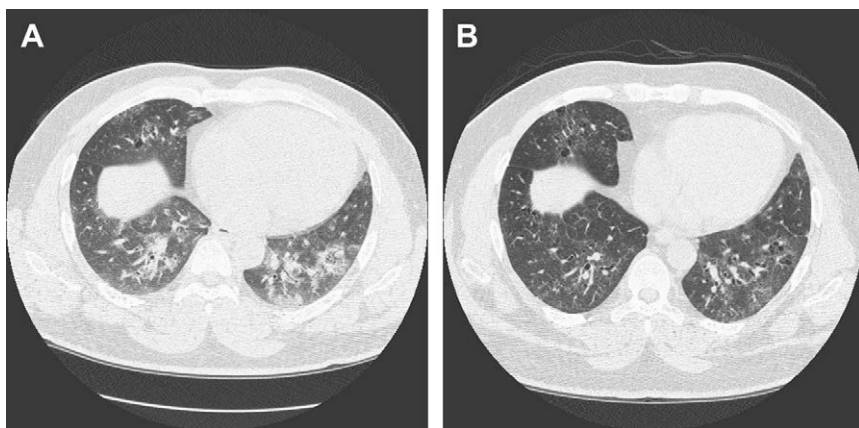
(A) A high-resolution chest CT in expiration showing patchy bilateral ground glass airspace opacification on a background of more chronic changes. Patient had no sicca complaints but had Ro antibody and positive glandular scintigraphy. (B) Same patient. A high-resolution chest CT with lung windows. There are extensive fibrotic changes predominantly at the lung bases showing interstitial thickening, mild traction bronchiectasis, and some bullous changes in the right middle lobe.
